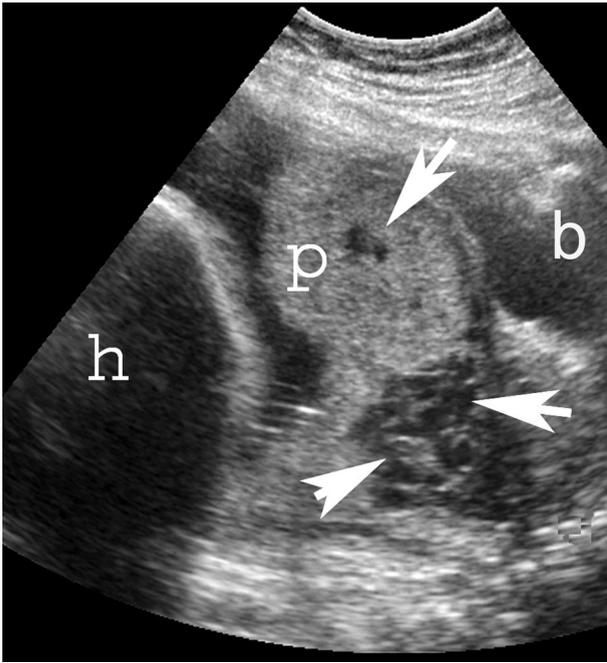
Grayscale sonogram of placenta percreta. Note the prominent placental lacunae (arrows) giving the lower uterine segment a “moth-eaten” appearance. The diagnosis was confirmed at delivery. *p*, placenta; *h*, fetal head; *b*, bladder.
